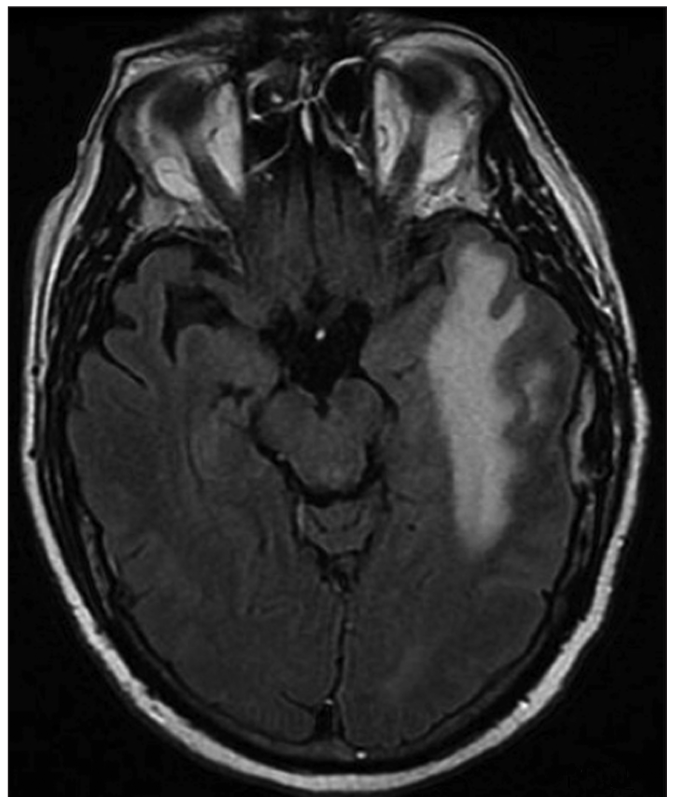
The patient's brain MRI one month prior to the onset of the acute infectious illness showing long-standing localized T2 hyperintensity in the area of the glioblastoma.
